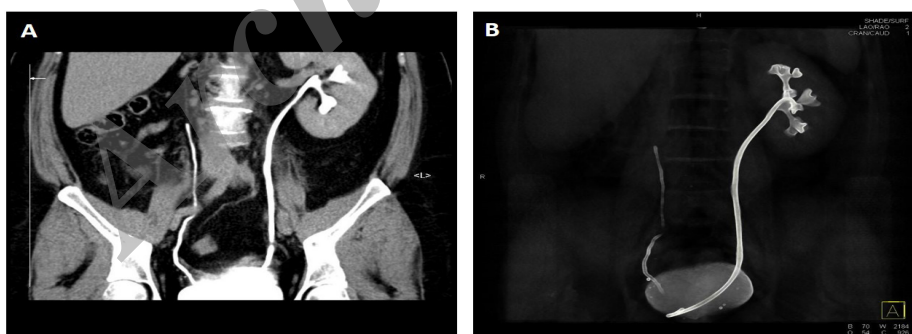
Excretory phase of computed tomography scan demonstrates retrograde opacification of distal, blind-ending, nondilated, nonobstructed right ureteral stump. Visualized structures suggested remnant of the incompletely developed right ureteral bud, with normal position of the right ureteral orifice. A) Coronal curved-planar reformatted; B) Volume-rendered image.
